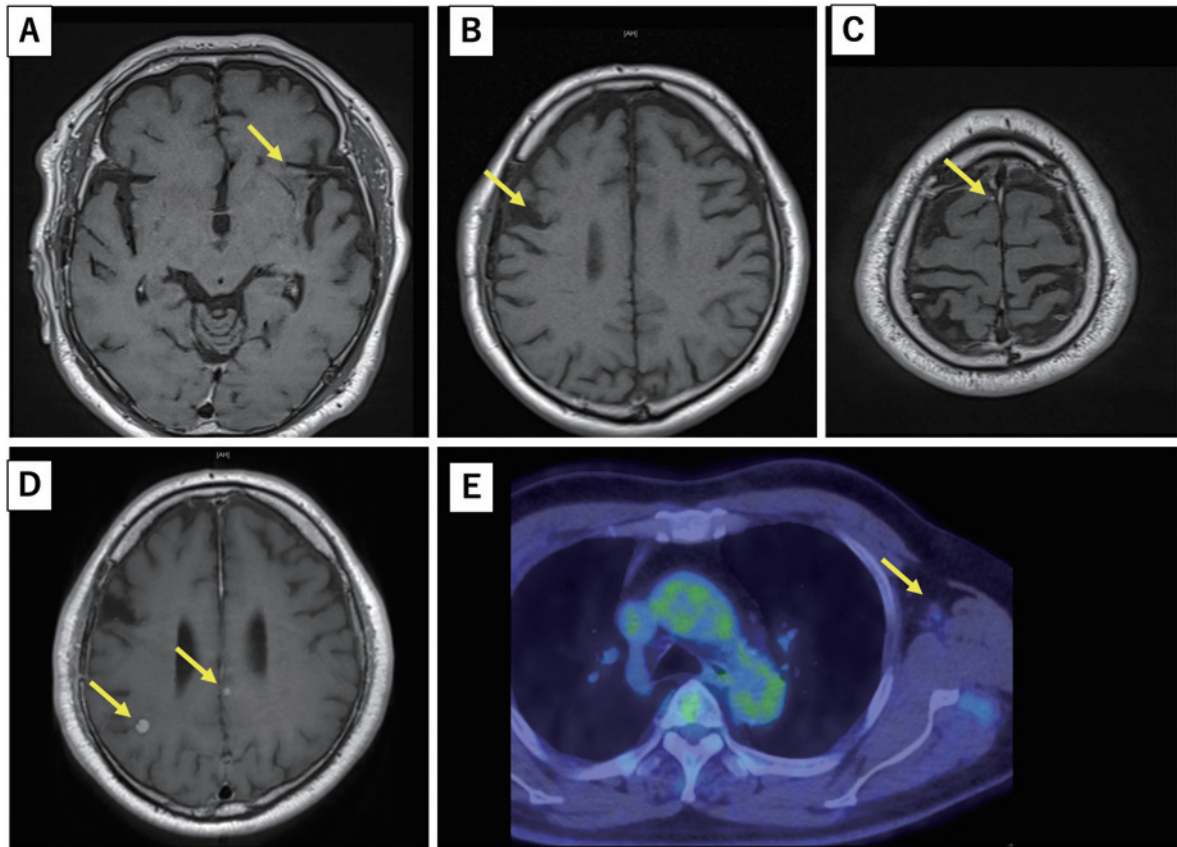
Postoperative images. One year after surgery, we did not observe any recurrence of locally treated lesions in the left basal ganglia and in the right frontal lobe investigated via MRI (T1WI enhanced by gadolinium) (A–C). After temporary interruption of systemic treatment, two lesions appeared in similar MRI images of the right parietal lobe and left cingulate gyrus (D). FDG PET-CT at 1 year after the start of molecular-targeted therapy shows that the high accumulation in the left axillary lymph node has disappeared (E).
